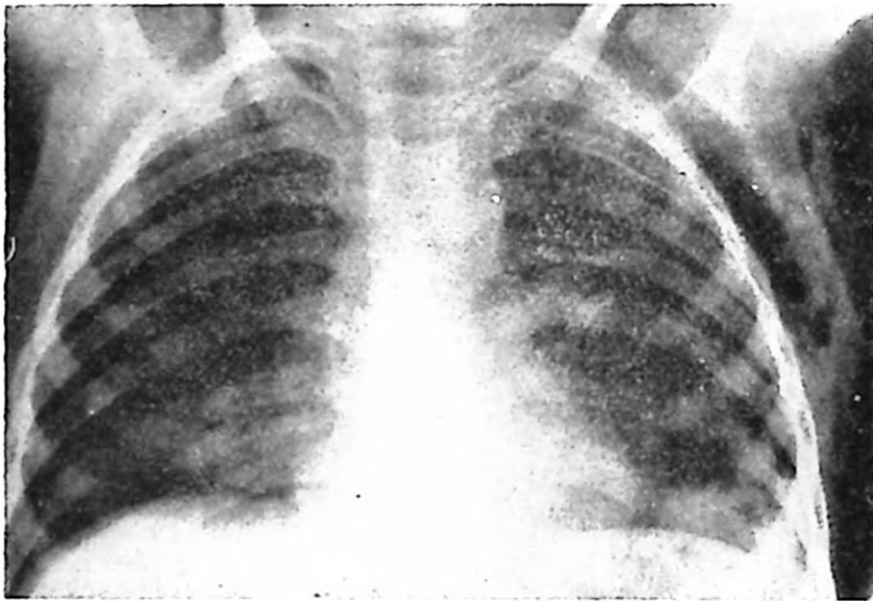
Same patient. Roentgenogram on 10/17/62 indicating reduction of pneumothorax on the right and disappearance of pneumothorax on the left.
